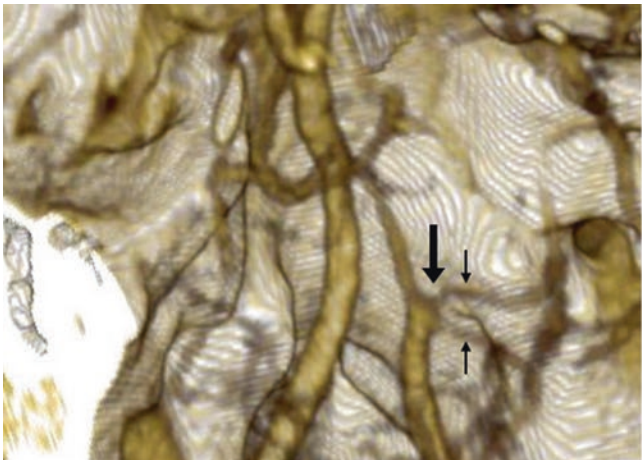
In this 61-year-old, 3D VR CTA PA views demonstrate a small (<1.5 mm) infundibular outpouching (*arrows*) of the right posterior inferior cerebellar artery (PICA) origin at the site of a PICA duplication (*thin arrows*), which arises from the apex of the outpouching
